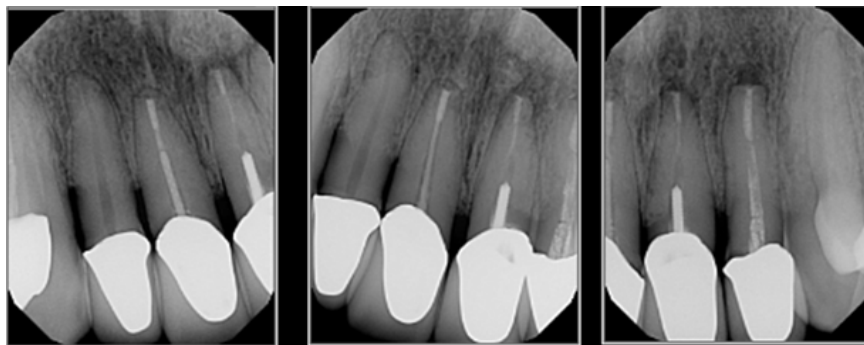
Pre-operative periapical radiographs, maxillary anterior teeth.
